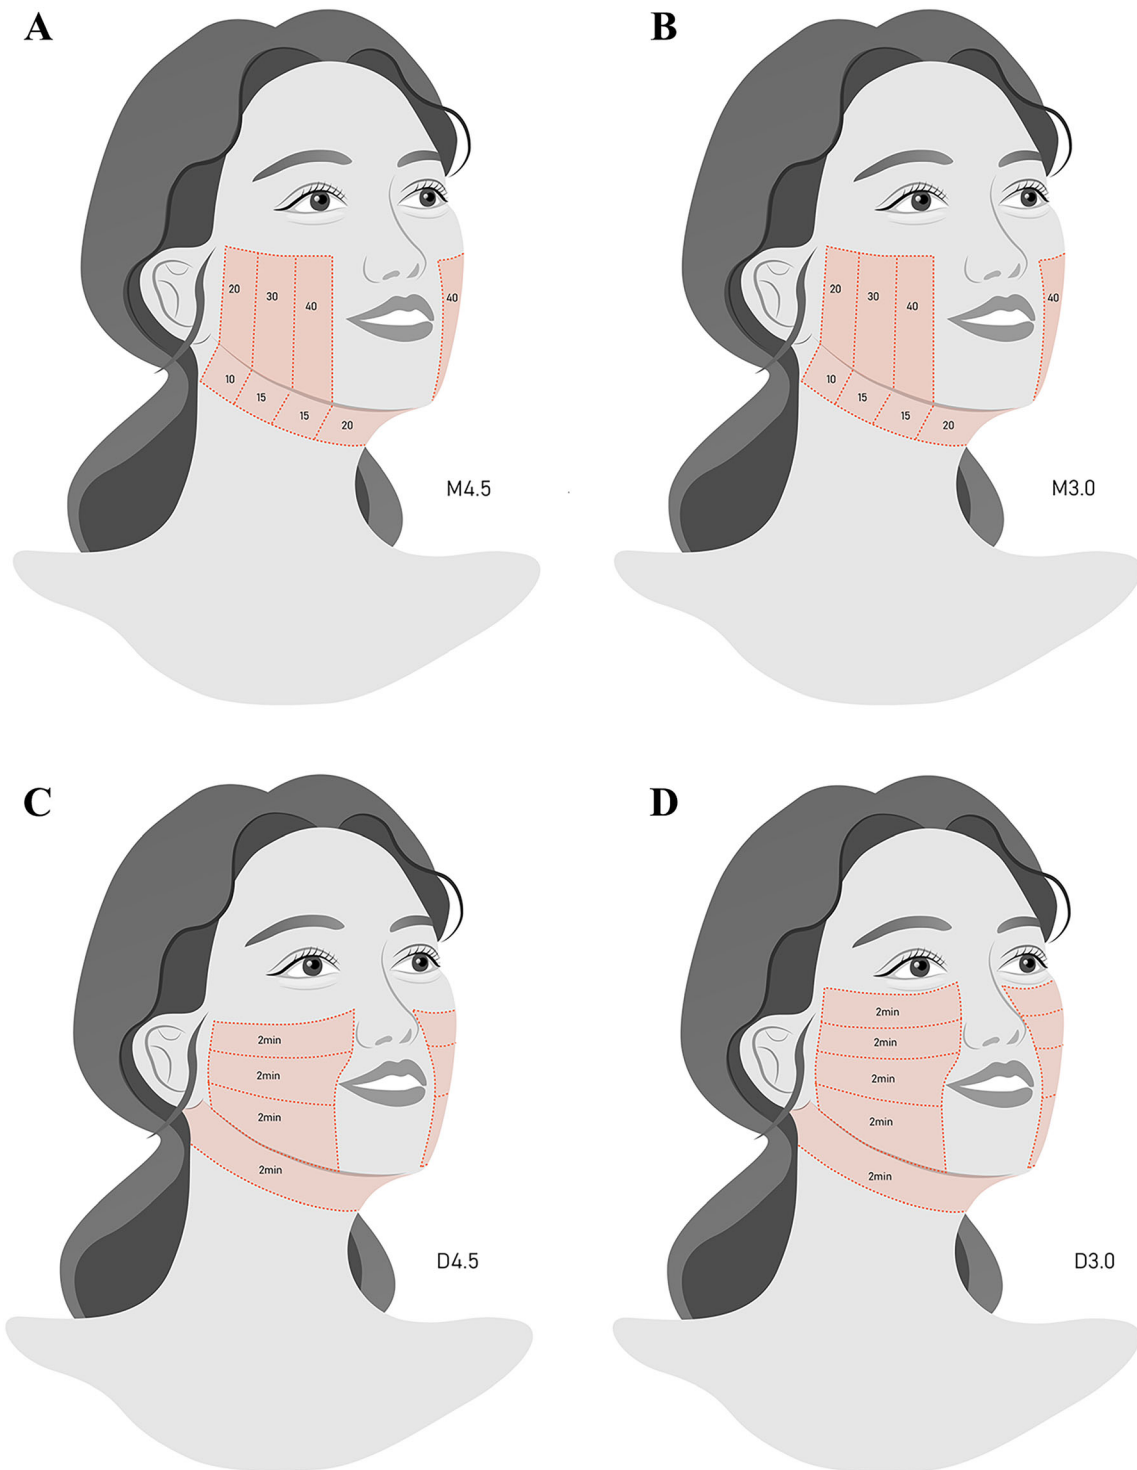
A–D Microfocused ultrasound system transducer selection and treatment exposure lines of the microfocused handpiece (A and B) and treatment exposure time of dot
